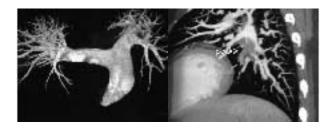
CT Pulmonary Angiogram showing filling defect in the descending branch of Left Pulmonary artery suggesting thrombus
